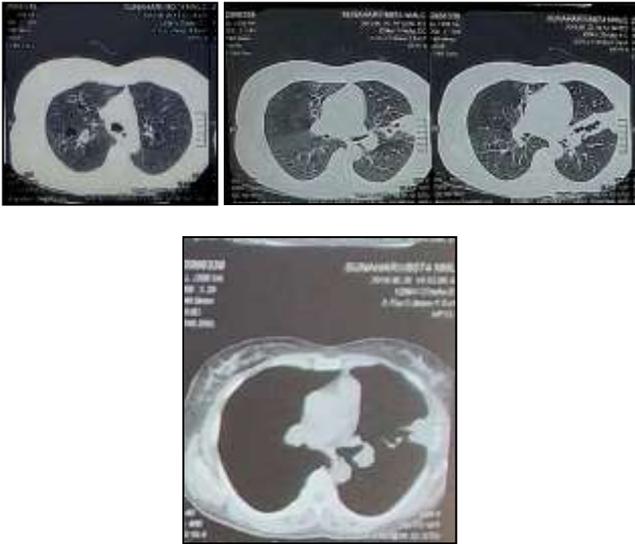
High-resolution computed tomography of the chest shows left lingular and right upper lobe bronchiectasis with centrilobular nodules in the right upper lobe and cystic changes in upper lobes of both lung fields and mild left side pleural effusion
